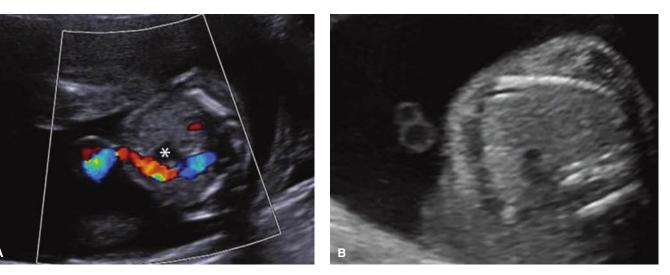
Two umbilical arteries are typically documented sonographically in the second trimester. They encircle the fetal bladder (*asterisk*) as extensions of the superior vesical arteries. A. In this color Doppler sonographic image, a single umbilical artery, shown in red, runs along the bladder wall before joining the umbilical vein (blue) in the cord. Remember with color Doppler that color signifies only blood flow direction relative to the transducer. B. A cross section of a floating cord segment shows the two vessels of the cord. The smaller circle is the single umbilical artery and the larger circle, the umbilical vein.
